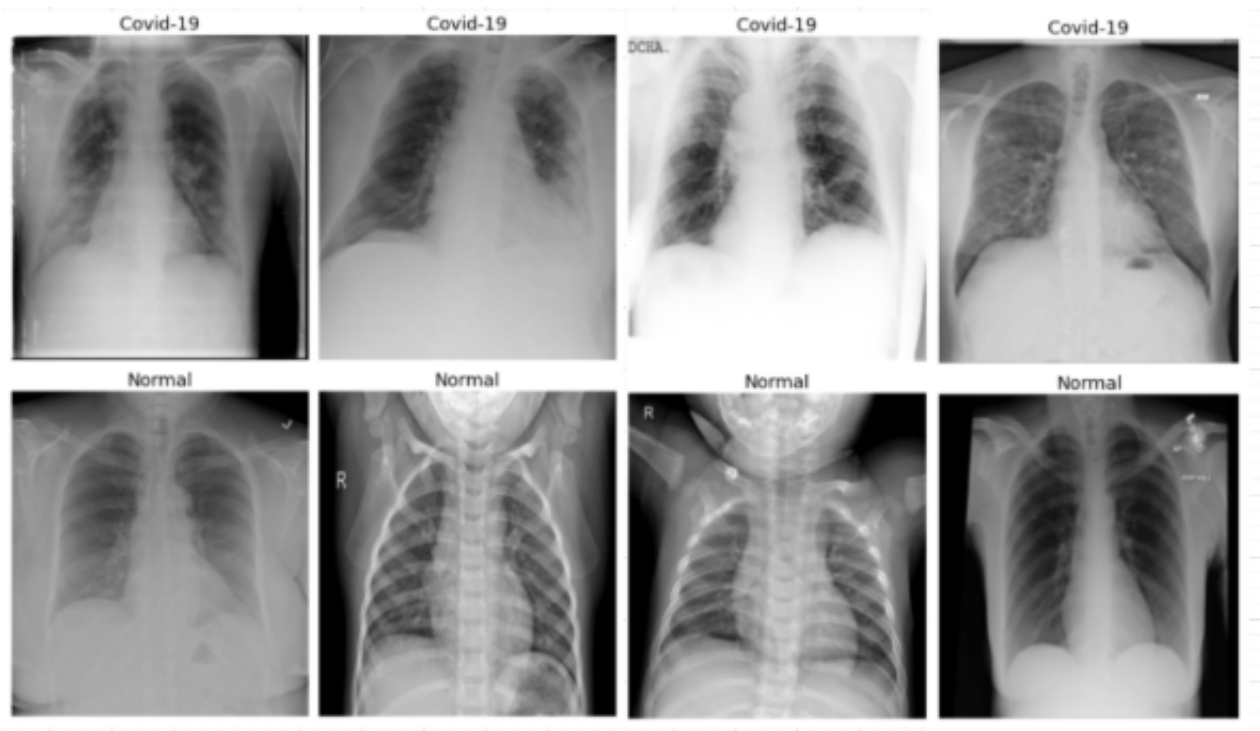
Sample image data(X-ray) for covid and normal class images for two class classification.
